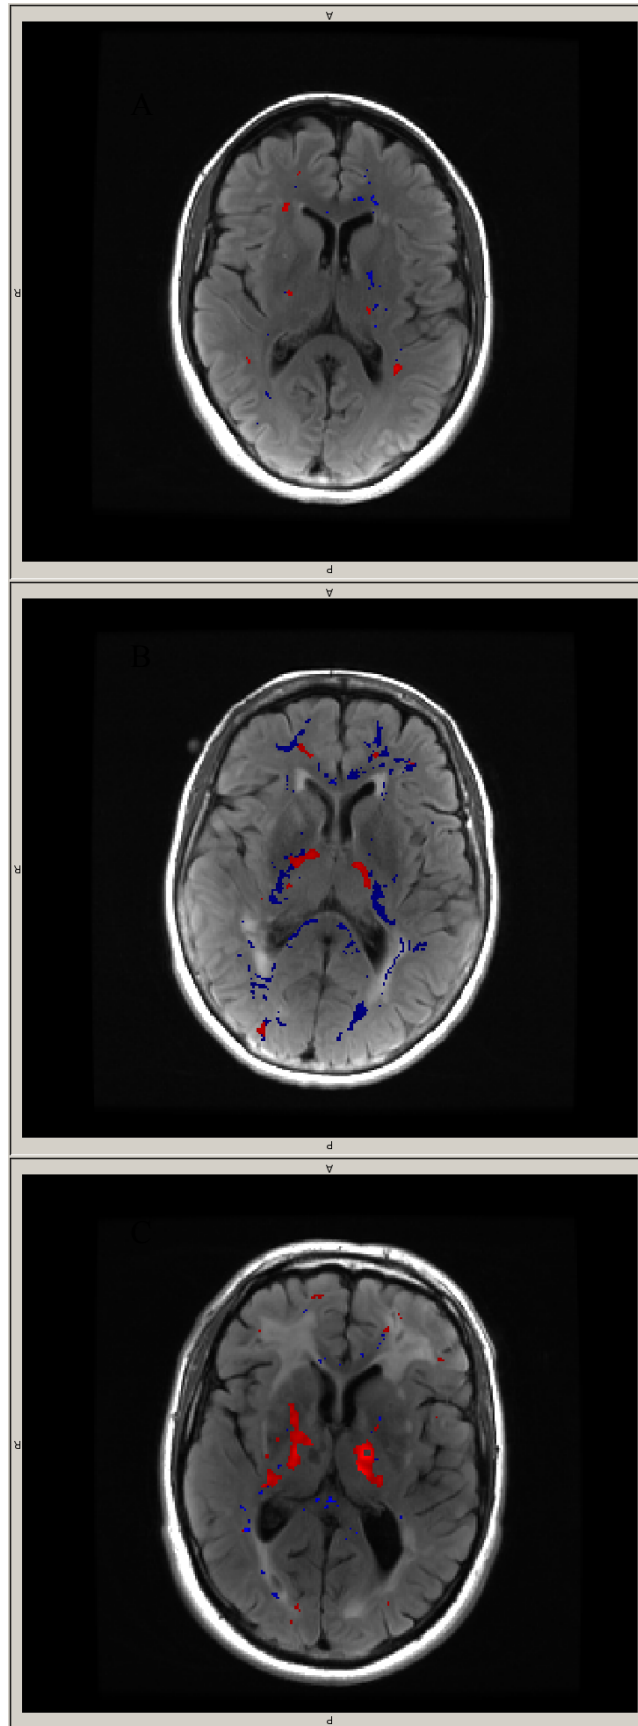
Example images of permeability (blue) and PK hotspots (red) overlaid onto T2 FLAIR scans. A) Control. B) Sporadic SVD. C) CADASIL.
